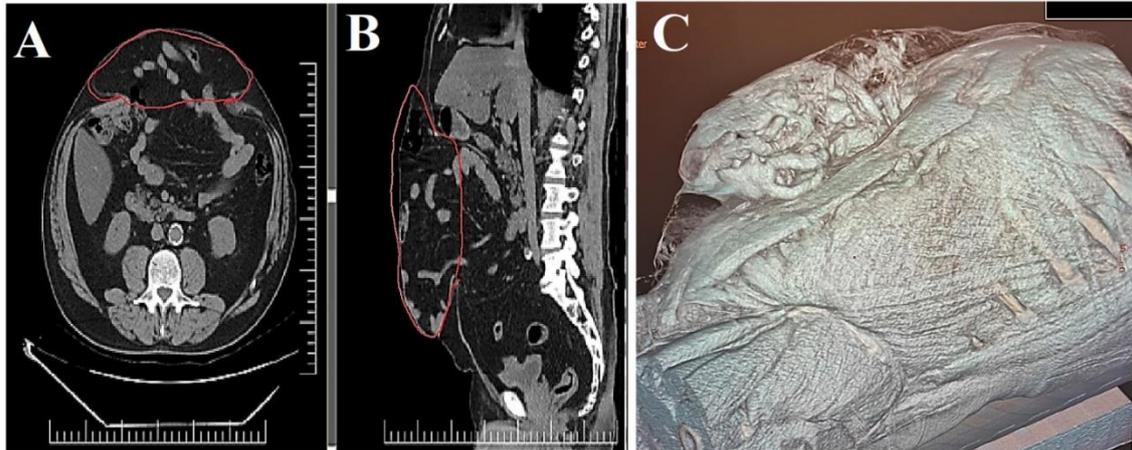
Preoperative CT scan. Note the CC and LL large diametr and volumes of incisional hernia sac and abdominal cavity. A. Transversal view; B. Sagittal view; C. 3D reconstruction
